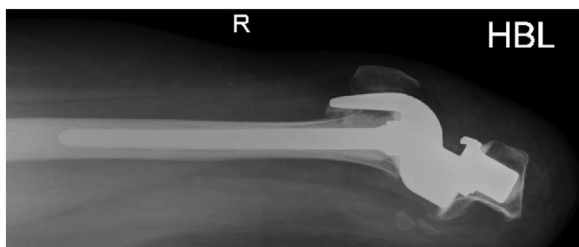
Postoperative radiograph of a right-sided, cemented total knee replacement, following a traumatic below-knee amputation 10 years previously. A short intramedullary alignment rod has been used; however, the jig was unstable intra-operatively due to poor bone stock.
